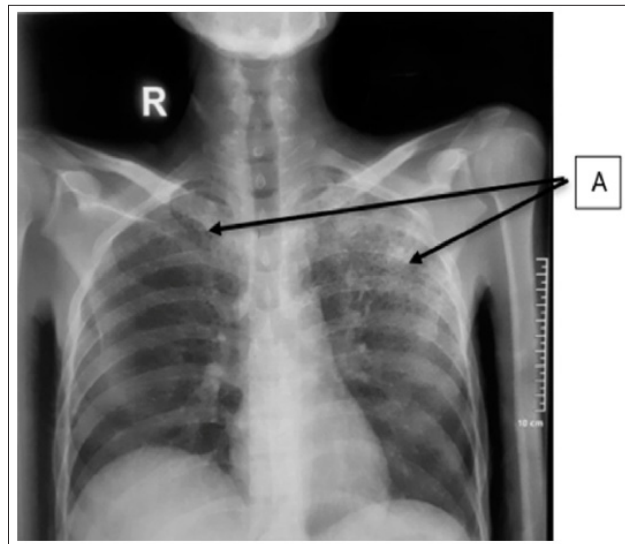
Xray of the Patient
